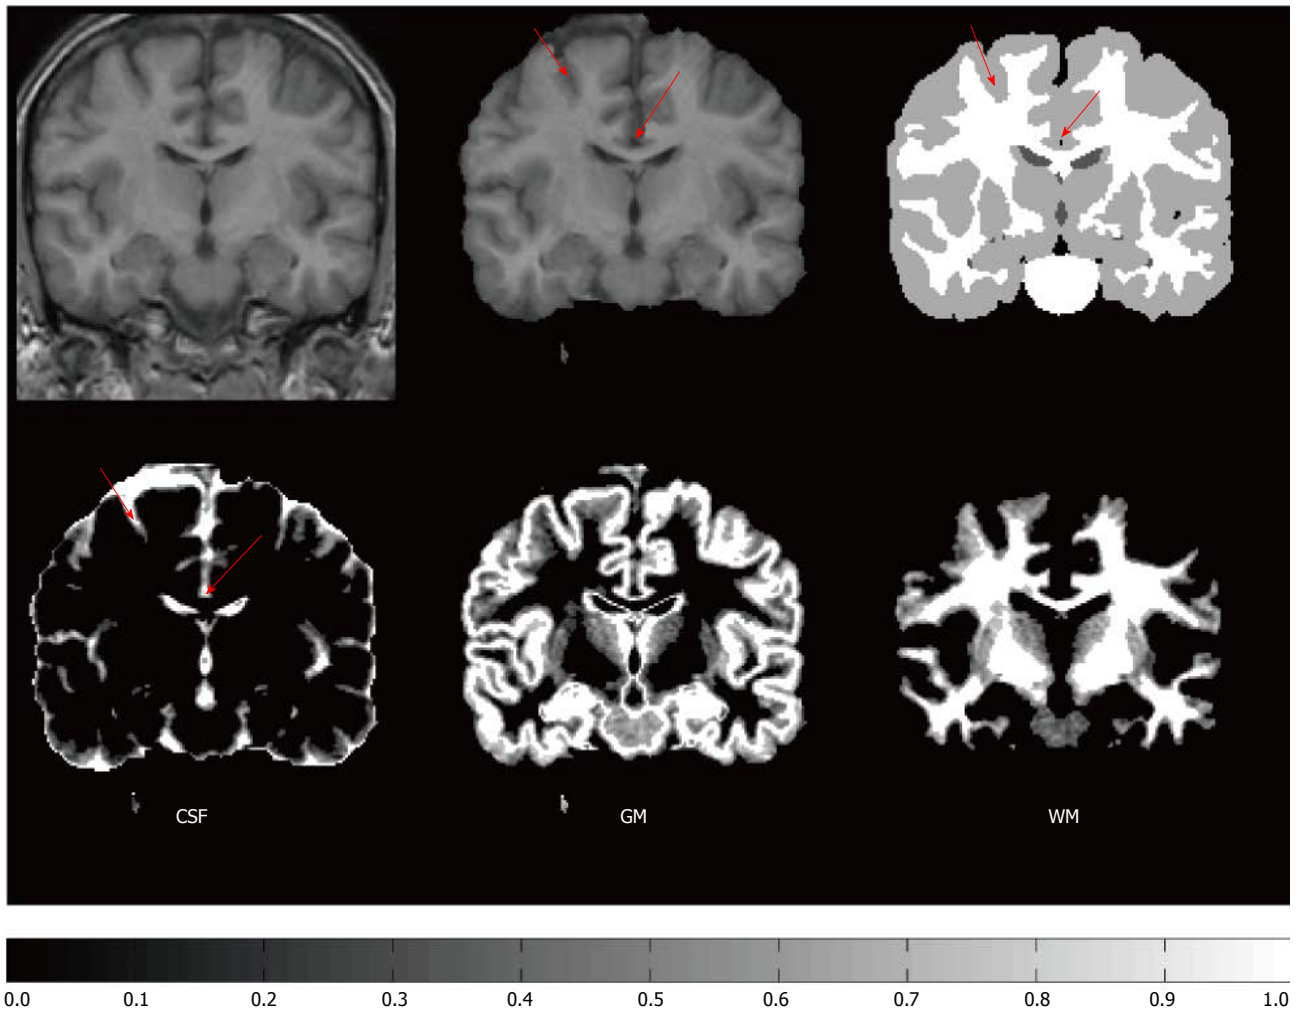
Example of partial volume estimation. Top row, from left: A coronal section of T1 weighted MR image; A skull stripped version of the coronal section; A manual labeling into gray matter (GM) (gray color), white matter (WM) (white color), and cerebro-spinal fluid (CSF) (dark gray color). Bottom row: Estimates of partial volume coefficients (PVCs) for CSF, GM, and WM. The color bar refers to the PVC estimates in the bottom row. The image is obtained from the IBSR2 dataset provided by the Center for Morphometric Analysis at Massachusetts General Hospital and PVCs were computed as described in the ref. [28]. Note how the manual hard labeling completely misses the CSF in the interhemispheric fissure as well as in the superior frontal sulcus pointed by red arrows. Instead PVC estimates of CSF in the bottom row capture well the sulcal CSF.
